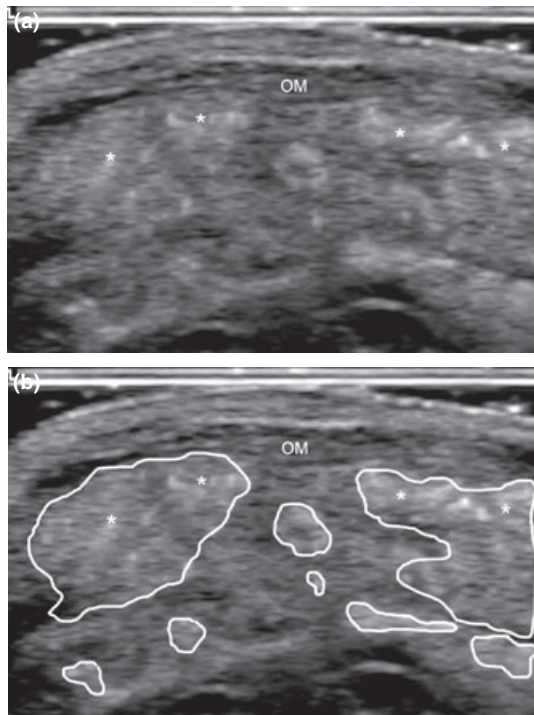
Polymethylmethacrylate (PMMA) dermatopathy. (a) Ultrasound (transverse view) shows PMMA deposits (*) as hyperechoic bright dots presenting posterior reverberance (mini comet-tail artefacts) spread within the orbicularis muscle of the upper lip. (b) Outline of PMMA deposits (within the white line). OM, orbicularis muscle of the lip.
